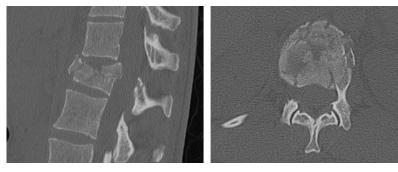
A CT scan of a thoracic fracture, seen in sagittal and axial CT images. The axial view to the right shows that the canal is patent. (Case courtesy of Radiopaedia.org, rID: 5274)
